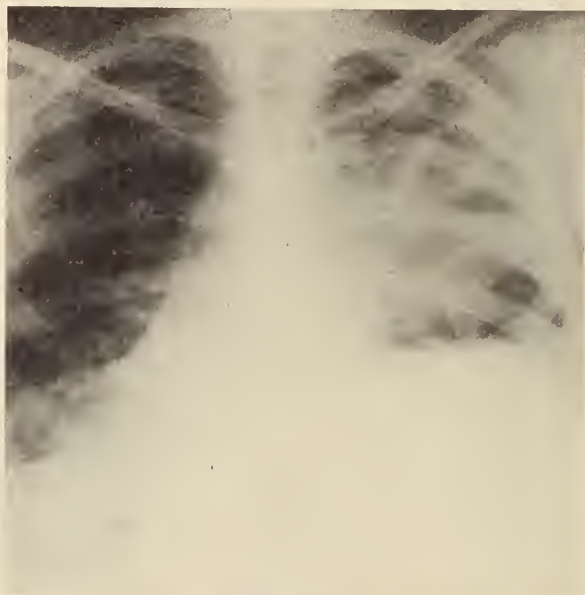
X-ray plate of the chest taken two days before admission to the hospital. This showed (1) a large amount of fluid and air in the left pleural cavity, (2) displacement of the heart to the right, and (3) multiple shadows in the right lung which were interpreted as multiple abscess cavities.
